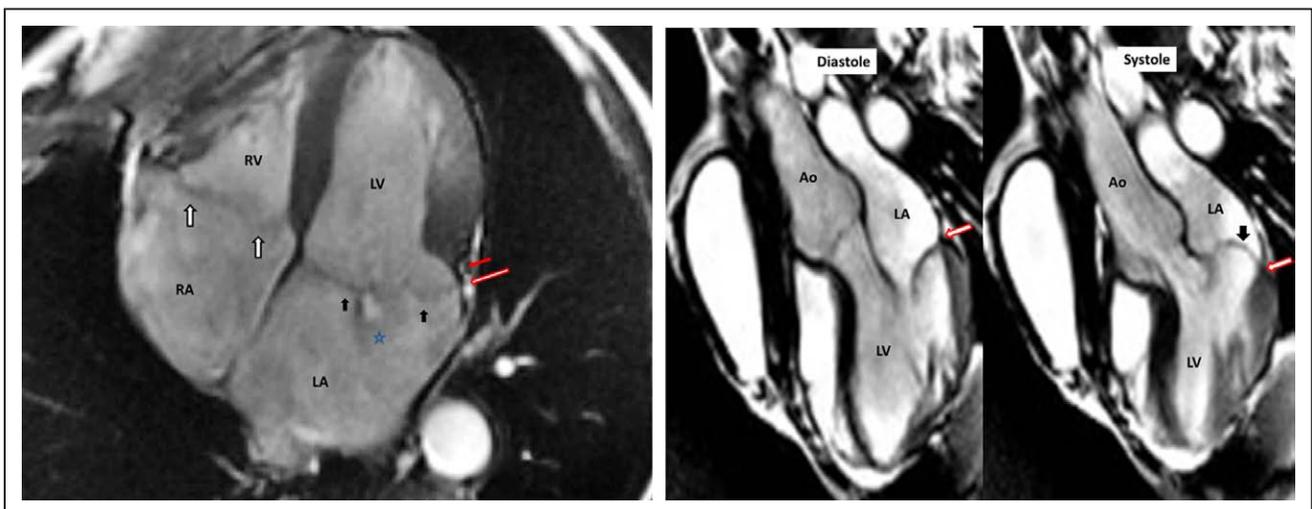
Magnetic resonance imaging of mitral valve prolapse with or without annular disjunction. A (left), Bileaflet prolapse with annular disjunction in systole: solid red arrow indicates the left ventricle (LV) wall tip, and the annular disjunction is measured by the distance to the red/white arrow located at the actual annulus position, solid black arrows indicate mitral prolapse, blue star indicates regurgitant jet, and white arrows indicate associated tricuspid prolapse. B (right), Mitral posterior prolapse without annular disjunction. The red/white arrow is located at the annulus level and is on top of left ventricular myocardium both in diastole and systole. Solid black arrows indicate the mitral prolapse. Ao indicates aorta; LA, left atrium; RA, right atrium; and RV, right ventricle.
